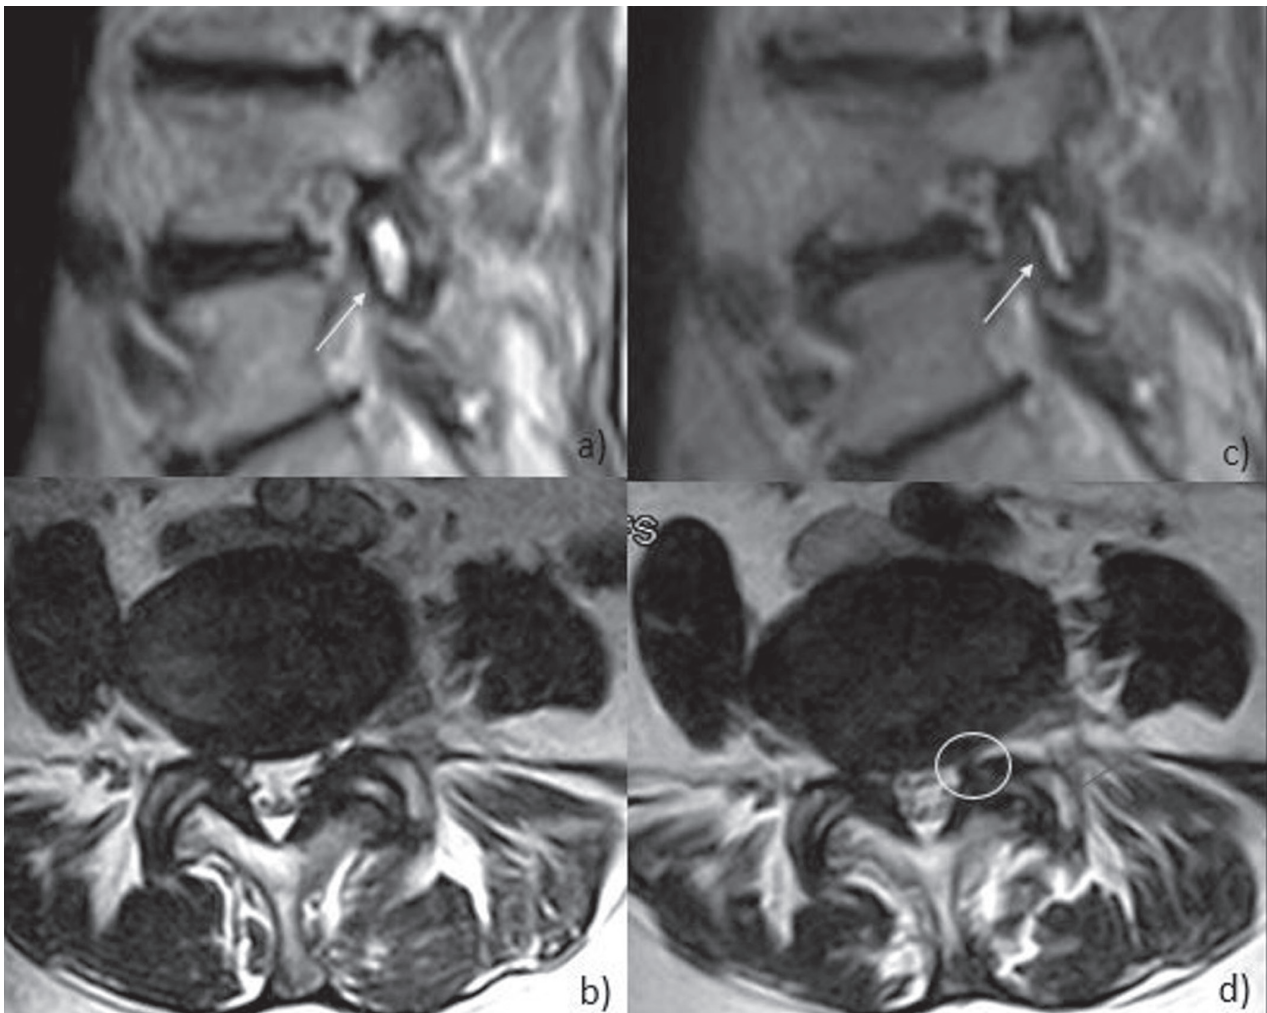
Fast spin echo (FSE) T2-weighted MRI images in the sagittal and axial planes in supine position (a, b) and in weightbearing position (c, d). The upright images show a reduction of conjugate phoramen and an anterior sliding of the right joint capsule with reduction of the neural foramen. The degree of disc and facet joint degeneration has a positive association with excessive translational motion while the degree of facet joint degeneration has a negative association with excessive angular motion
